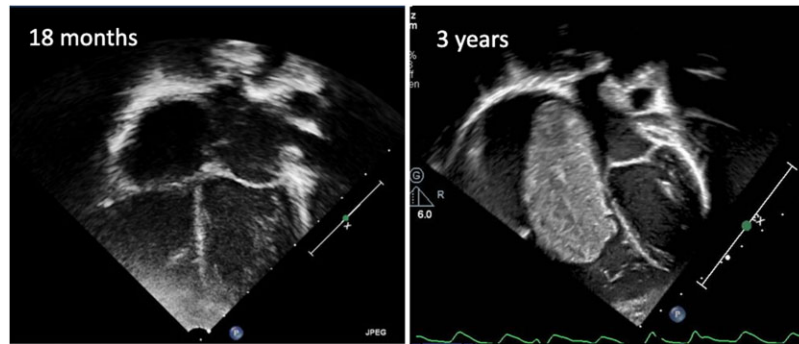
Normal echocardiogram at 18 months old and abnormal echo at 3 years old. Apical four-chamber view demonstrating a new large solitary mass (6.4 × 3.1 cm) originating in the right atrium and protruding through the tricuspid valve.
